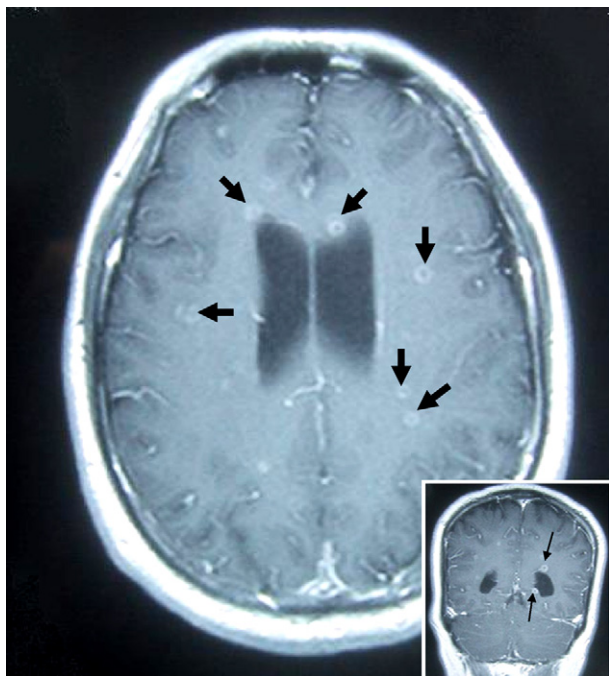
Magnetic resonance imaging scan of the head performed two days after presentation revealed multiple 5-mm ring-enhancing lesions, both supratentorial and infratentorial, throughout the cerebral hemispheres, compatible with septic emboli and microabscesses (arrows).
